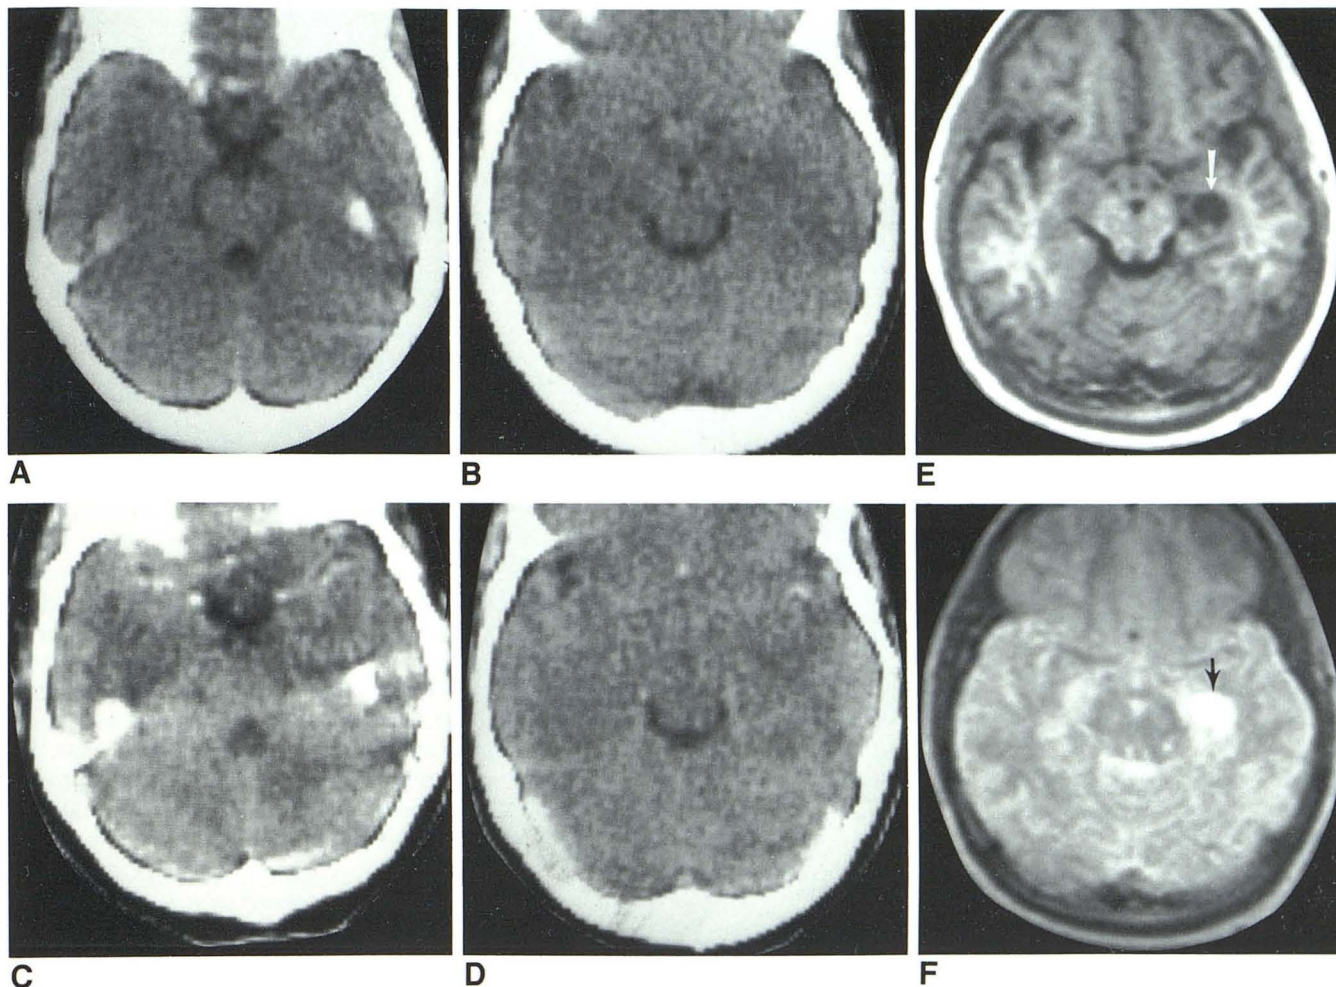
Case 3. A and B, Contiguous 8-mm-thick normal unfused CT scans. C and D, Normal postinfusion CT scans. E, IR 1400/400 image. Comma-shaped lesion of low signal intensity in left medial temporal lobe (*arrow*). F, SE 4000/80 image. Abnormal comma-shaped area of high signal intensity in medial temporal lobe (*arrow*).
